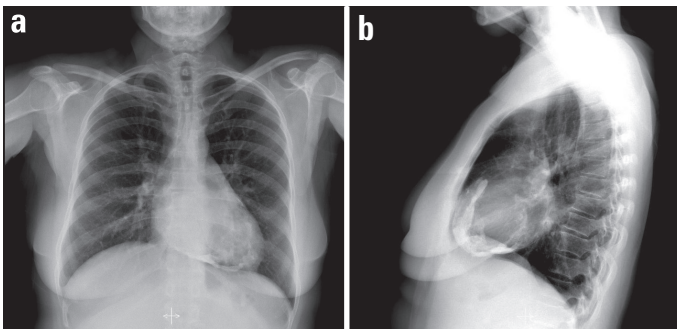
Chest X-ray (posteroanterior and lateral views) showing dense pericardial calcification
